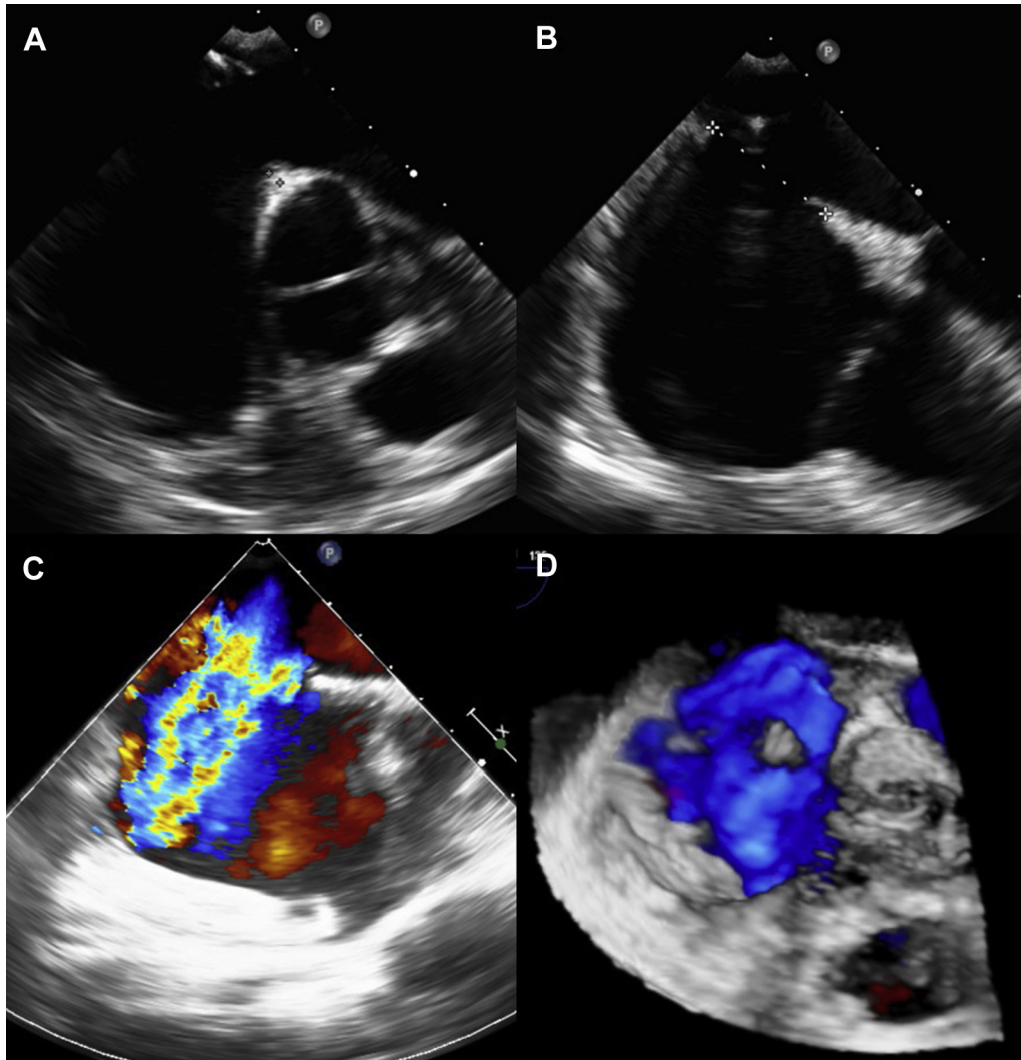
Intraprocedural transesophageal echocardiogram from case 1 after cryoballoon ablation demonstrates a large iatrogenic septal defect with inadequate rims (A, B) and large left-to-right shunt by color imaging (C, D).
